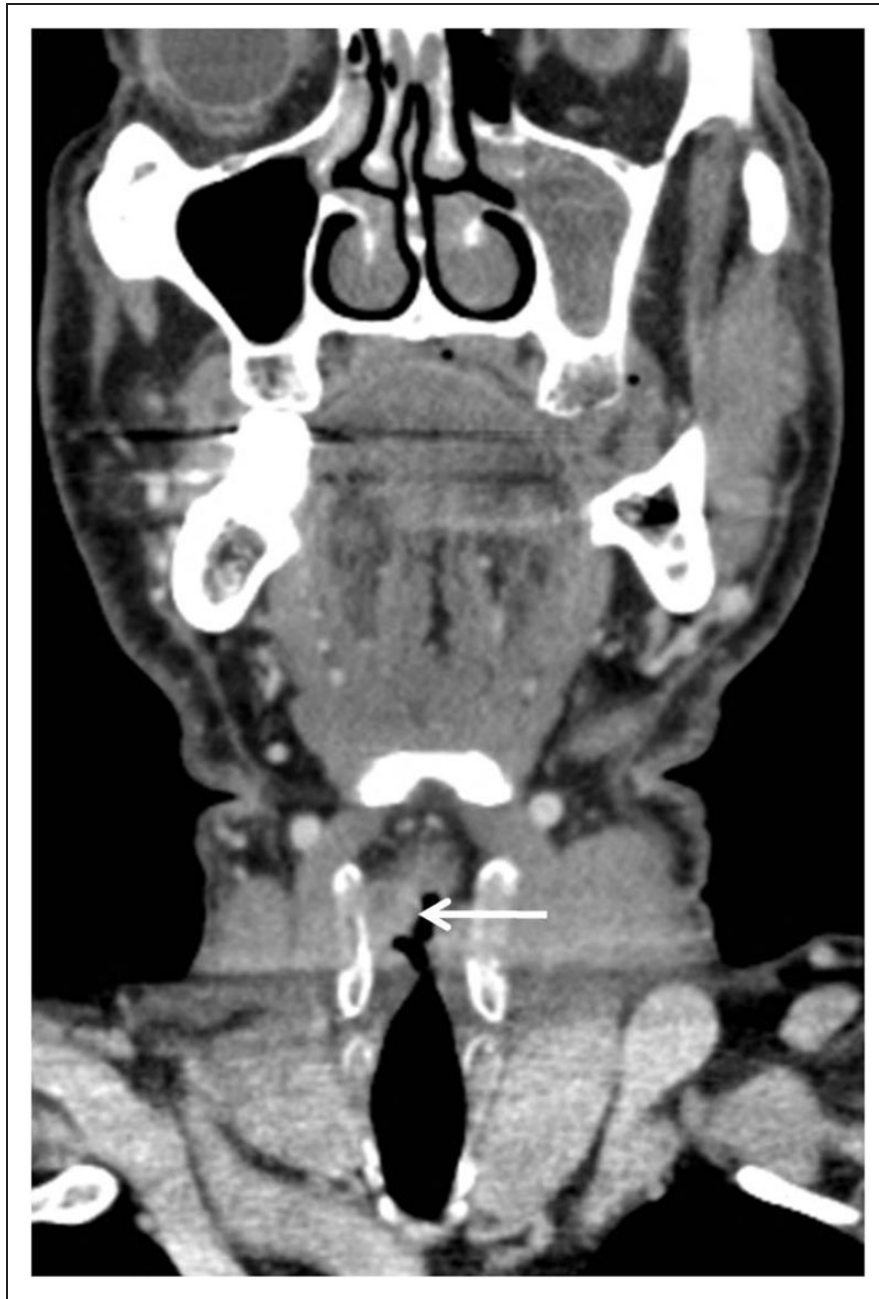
Coronal contrast-enhanced computerised tomography (CT) image obtained in a 65-year-old man shows a trans-glottic squamous cell carcinoma (SCC) (arrow) involving the true and false right vocal cord.
